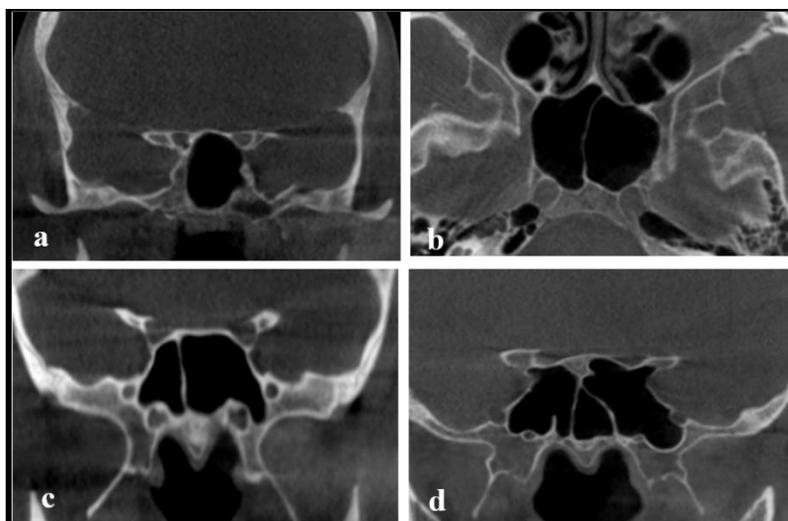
Coronal and axial cuts of CBCT showing configuration of the sphenoid sinus: a) Coronal cut (solitary type), b) Axial cut (paired symmetrical), c) Coronal cut (paired asymmetrical), d) Coronal cut (compound sinus)
